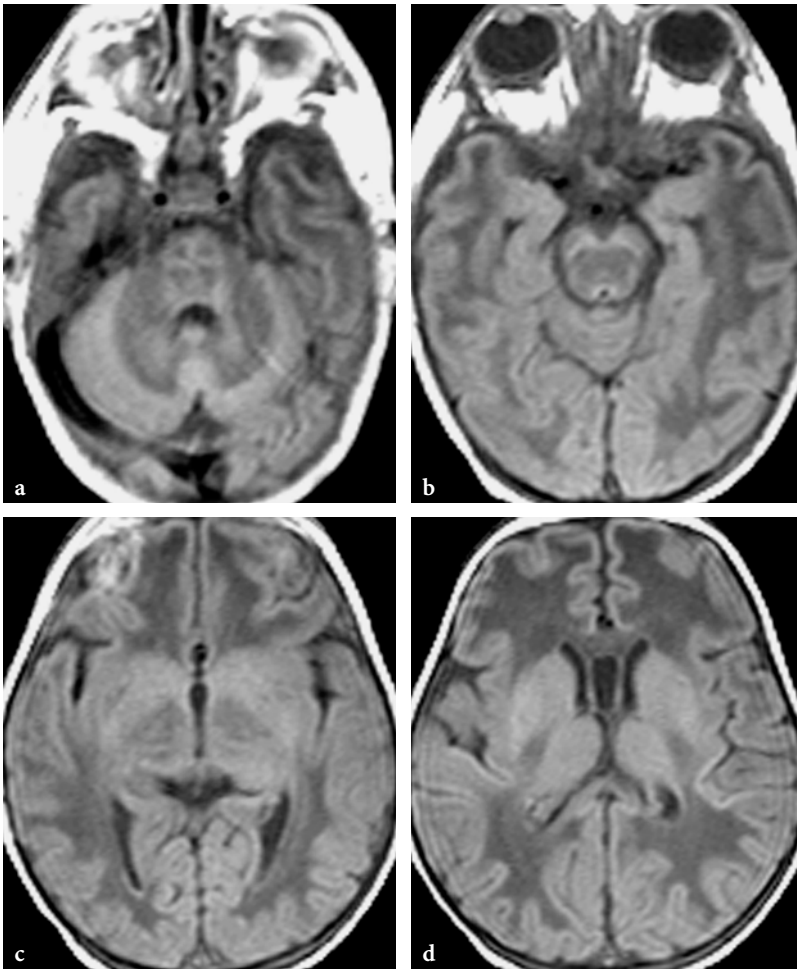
Axial T1-weighted spin-echo images in an 8-day-old female patient immediately after the onset of maple syrup urine disease. a-d Both myelinated and nonmyelinated white matter structures exhibit an abnormal, hypointense appearance. In this case the brain edema is rather mild
